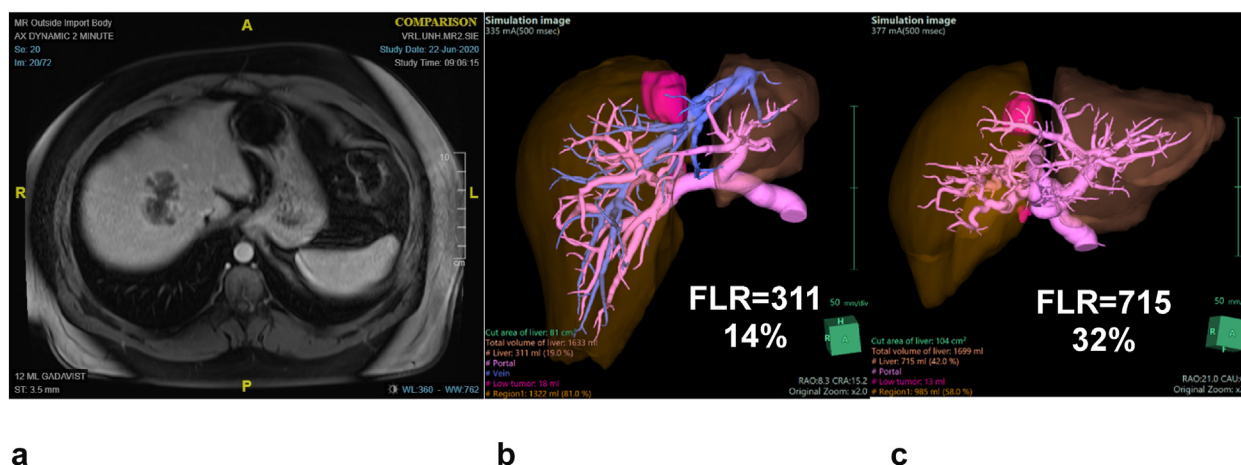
MRI depicting dominant tumor in dome of liver around segments 7/8/4A (a). 3D-reconstruction with volumetric analysis using specialized software (Synapse - FUJIFILM®) of the future liver remnant (left lateral section) before (b) and after (c) right portal vein embolization. Note: sTLV = 2,223 cm³ is significantly higher than the measured TLV = 1,699 cm³. Outcomes have been validated using the sTLV formula
